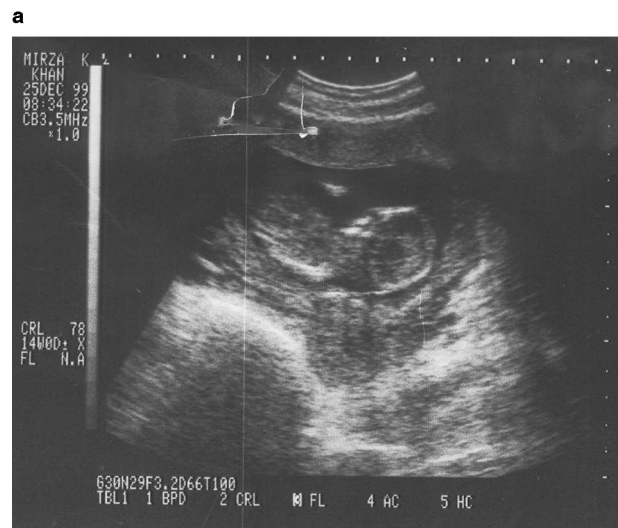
Ultrasonographic appearance of (a) an intrauterine singleton pregnancy and (b) an ovarian enlargement associated with multilobular ovarian cystic structure.
